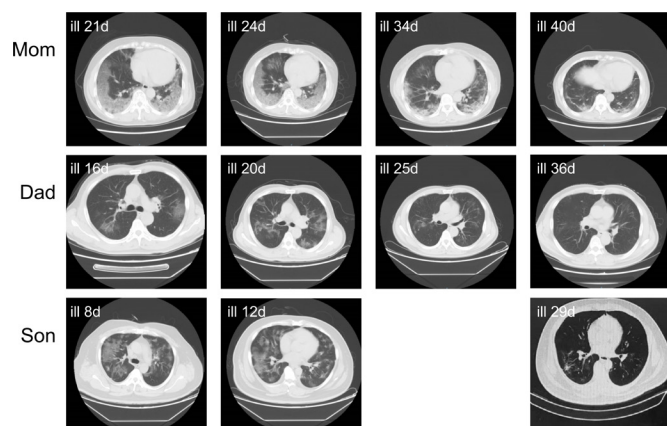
Chest CT scans of the three patients. The mother's lung shows a peripheral lesion with increased intensity and bilateral patchy shadows in the outer zones. Multiple patchy or segmental ground-glass opacities were observed in both lungs of the father and the son.
